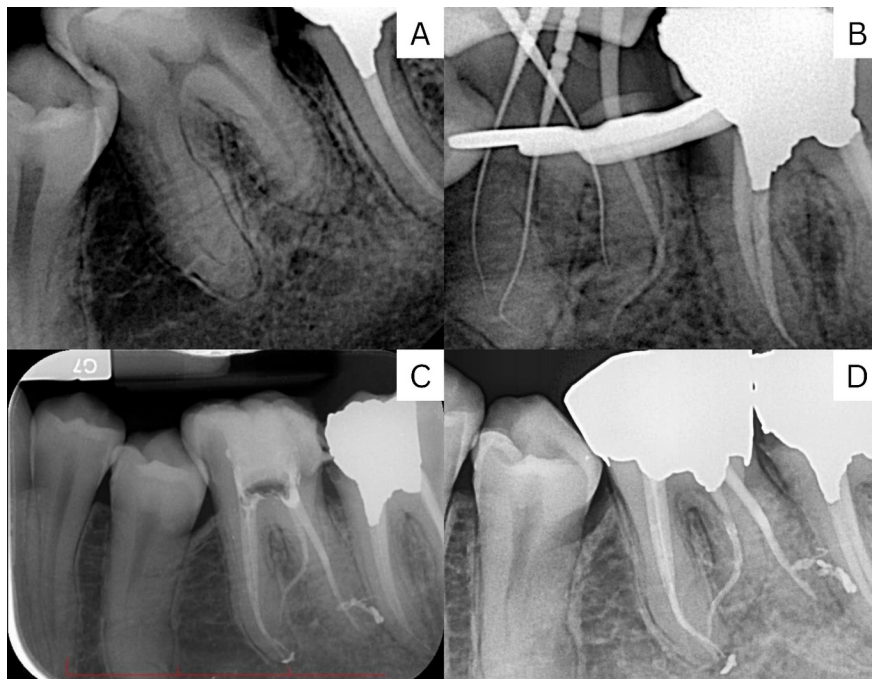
Figure First molar on the left side of the mandible: A) initial radiograph, extensive distal caries, PDL widening, S-shaped canals; B) working length determining; C) final radiograph, obturation, apical seal, temporary restoration; D) 18-month follow-up, coronal seal
